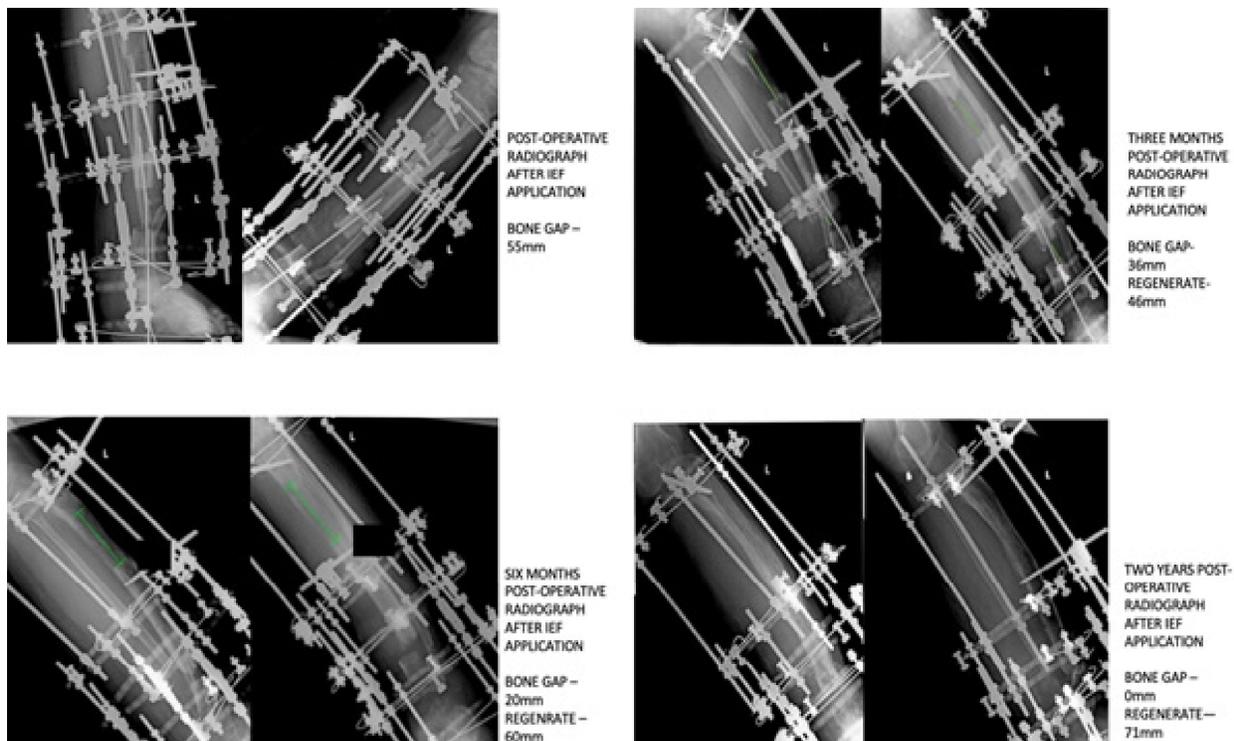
Series of events radiographically after IEF application and their follow ups as to the measurement of the regenerate formed throughout
